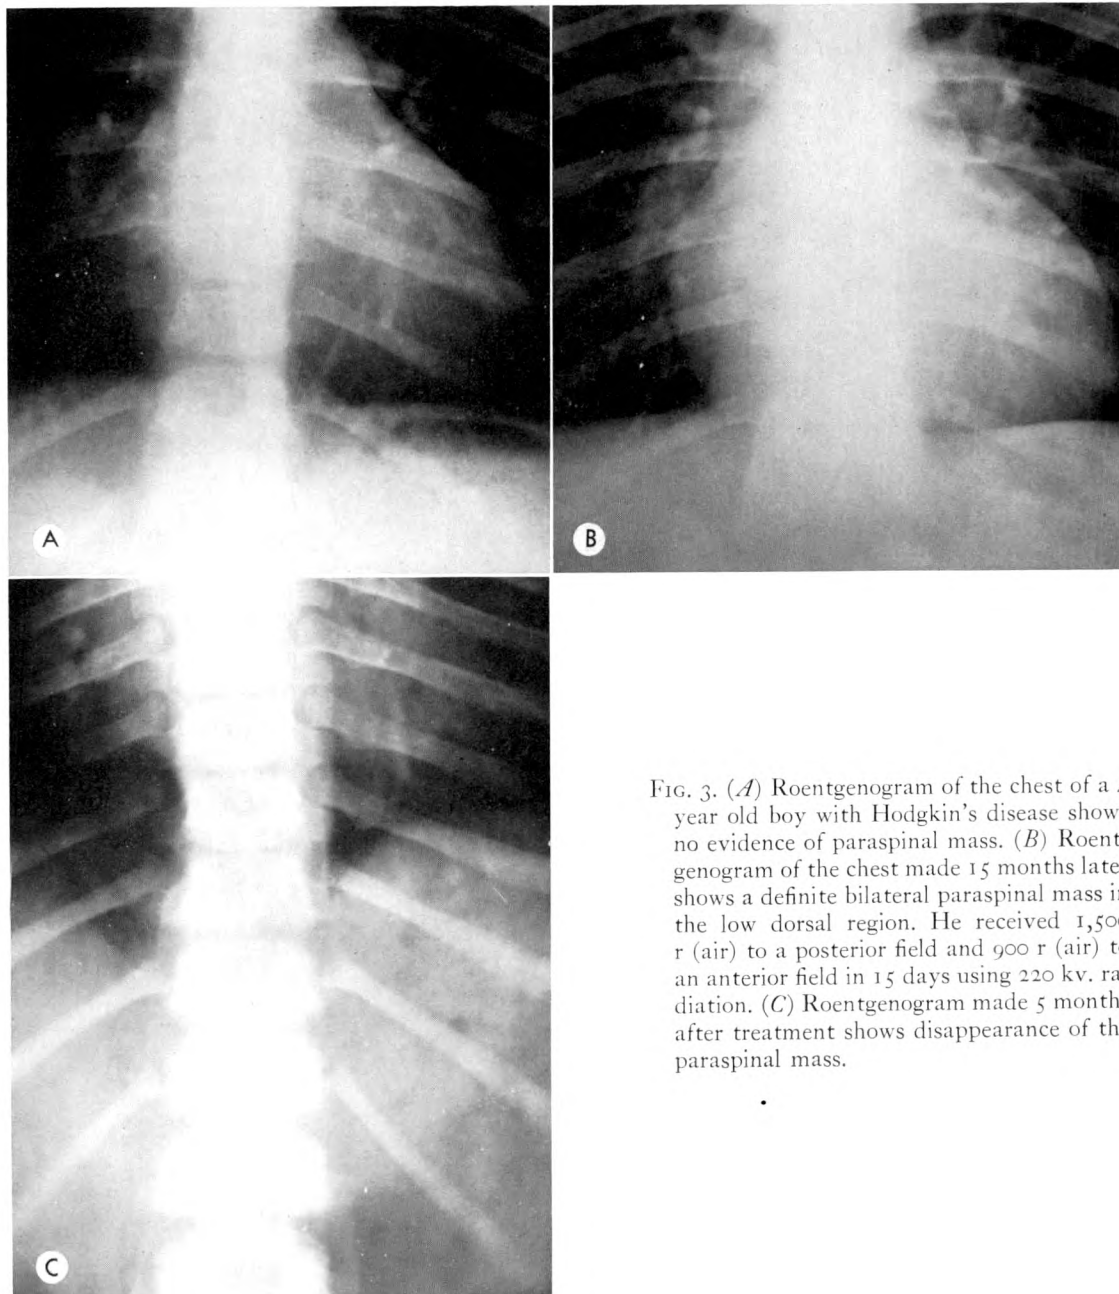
(A) Roentgenogram of the chest of a 4 year old boy with Hodgkin's disease shows no evidence of paraspinal mass. (B) Roentgenogram of the chest made 15 months later shows a definite bilateral paraspinal mass in the low dorsal region. He received 1,500 r (air) to a posterior field and 900 r (air) to an anterior field in 15 days using 220 kv. radiation. (C) Roentgenogram made 5 months after treatment shows disappearance of the paraspinal mass.
